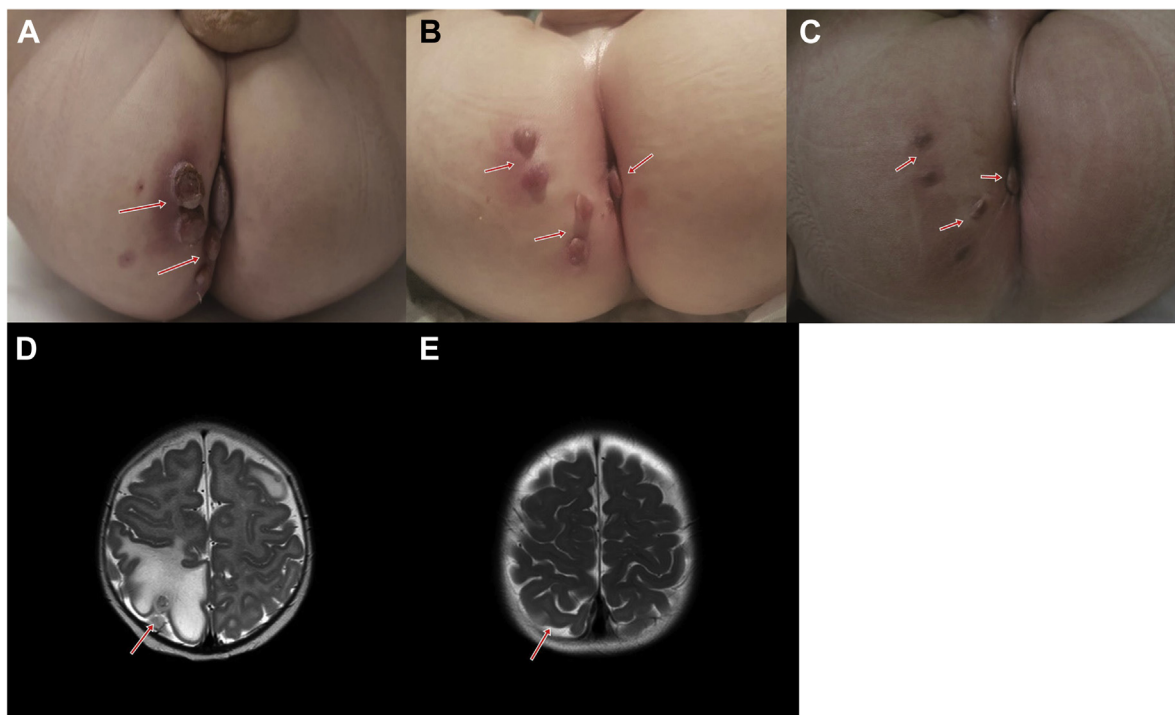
Patient 1 with infantile hemangioma (IH) affecting the whole body at the beginning of therapy (A), after 3 months of sirolimus treatment (B), and after 1 year of sirolimus therapy (C). Axial T2-weighted magnetic resonance imaging (MRI) of patient 1 showing intracranial hemangioma before the initiation of sirolimus (D) and after 6 months of sirolimus therapy (E).
